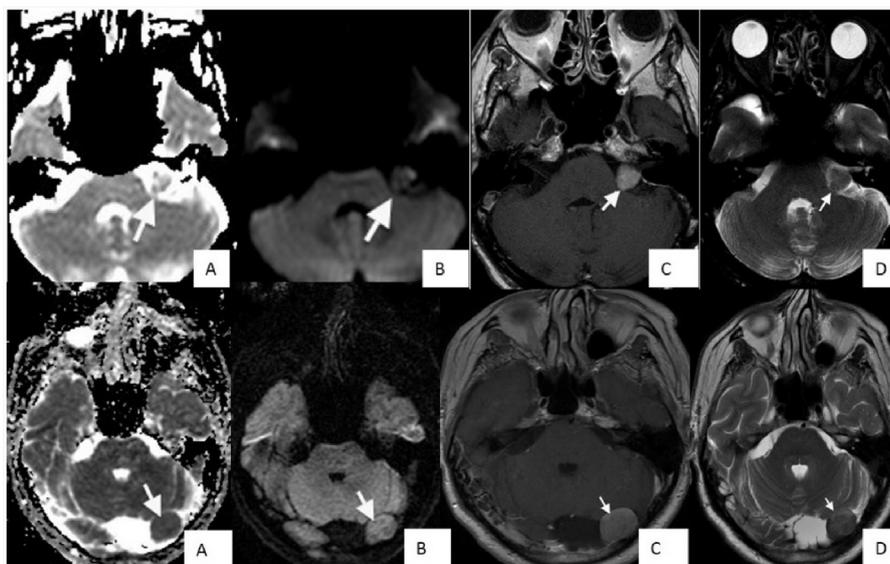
The top row is Patient 4 with hemangiopericytoma showing heterogeneous appearance and the bottom row is Patient 7 with meningioma showing homogenous appearance on A. Apparent diffusion coefficient (ADC) map. B. Diffusion weighted imaging (DWI). C. Post gadolinium T1. D. T2 images, with a mean ADC value at 1060.37 mm^2/s in hemangiopericytoma and 856.77 mm^2/s in meningioma.
